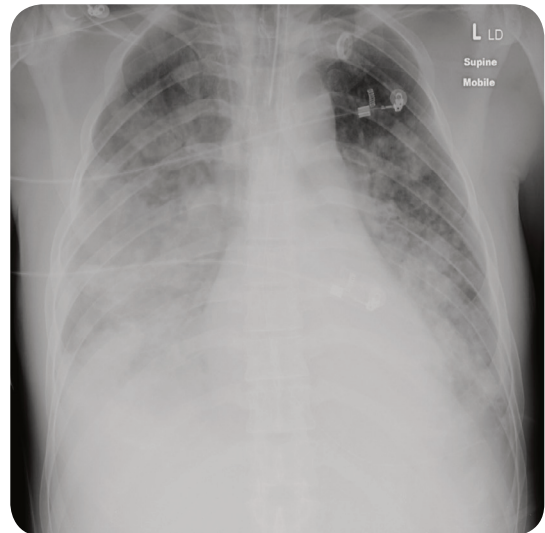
A chest radiograph demonstrating diffuse, bilateral, coalescent opacities resembling ground glass.
